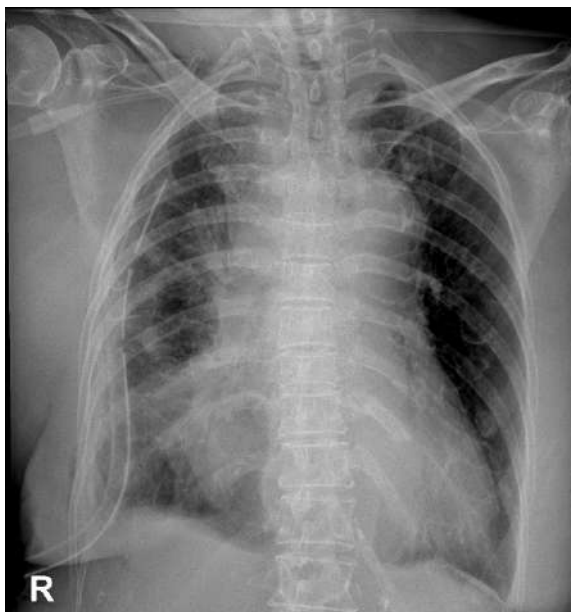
AP chest radiograph findings: A partially ill-defined opacity is visible in the right paracardial region, projecting to the level of the right paravertebral spaces at T8–11 and forming an obtuse angle with the mediastinum; silhouette sign (+)
